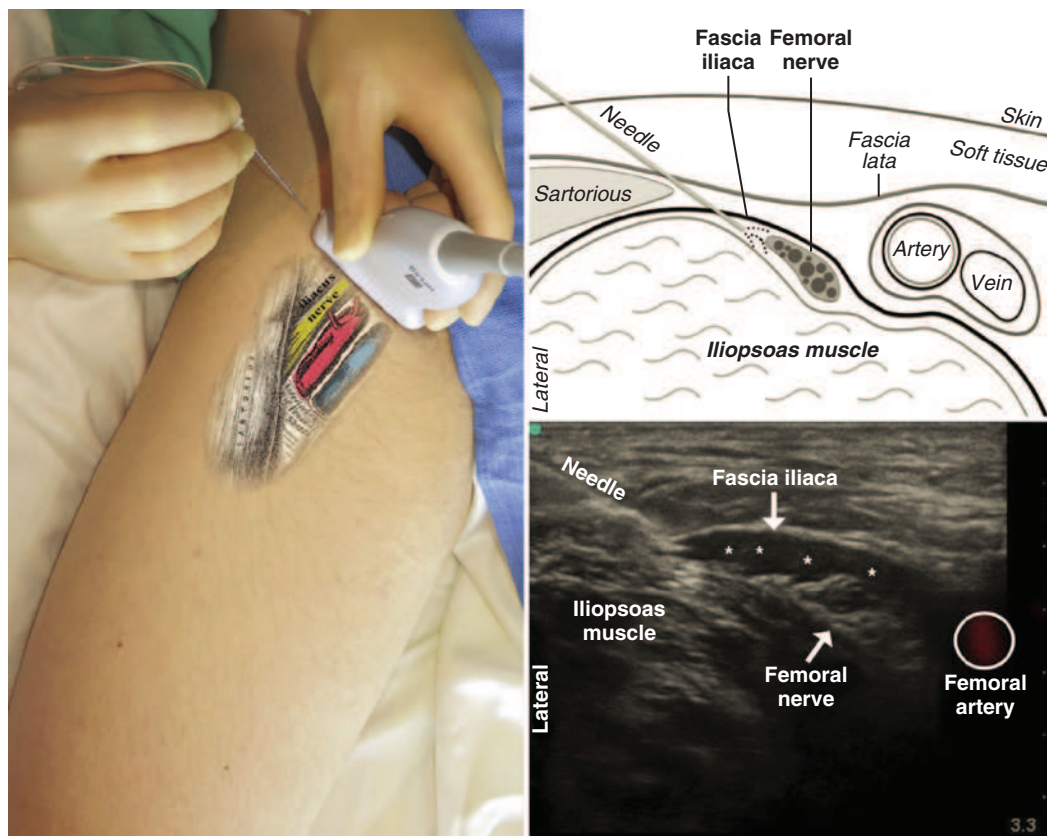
Ultrasound-guided femoral nerve block. The femoral nerve is most conveniently targeted with a lateral-to-medial, in-plane approach just above the inguinal crease, proximal to the femoral artery bifurcation. Here, the femoral nerve runs just underneath the fascial covering (fascia iliaca) of the iliopsoas muscle and lateral to the femoral artery. Local injection should flow underneath the fascia iliaca and surround the nerve.
